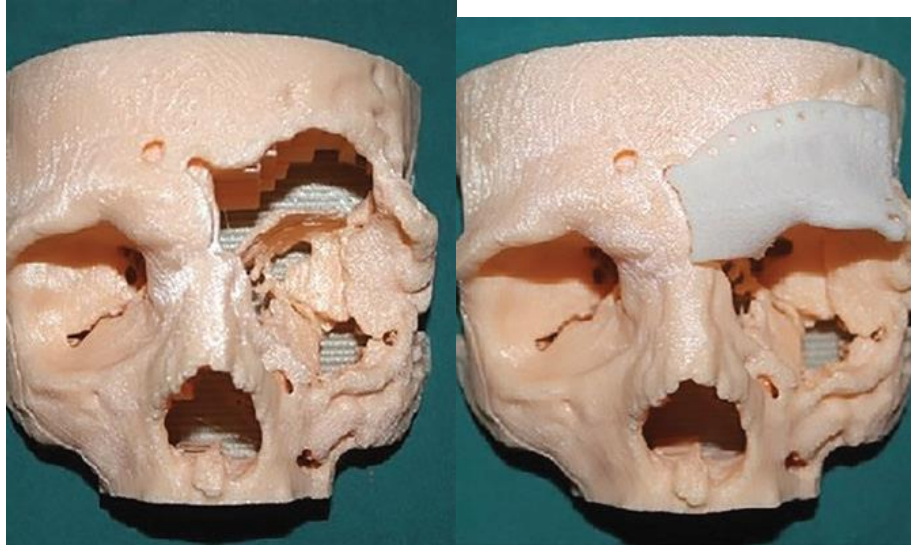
Shows the process of designing and manufacturing a patient-specific prosthesis in the orbital region. (a) Processing patient data from CT scan, (b) designing patient-specific prosthesis, (c) printed model of the patient's skull structure, (d) a piece of prosthetic model manufactured to match the patient defect precisely (42).
